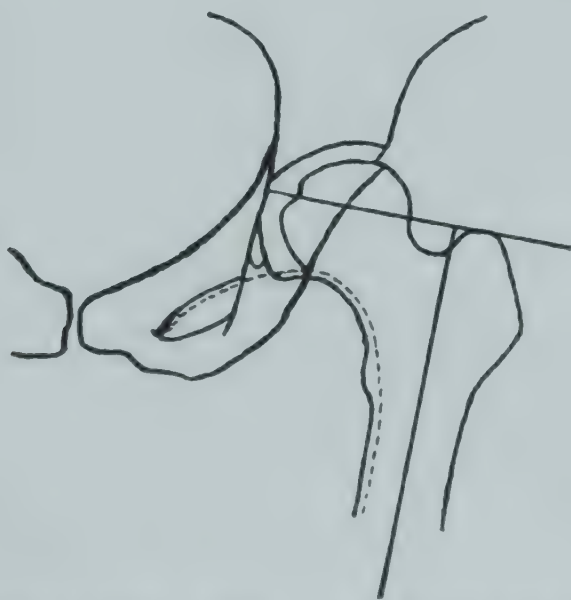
Angle neck to shaft of femur. (Sante, L. R.: Manual of Roentgenological Technique, Edwards Brothers.)
